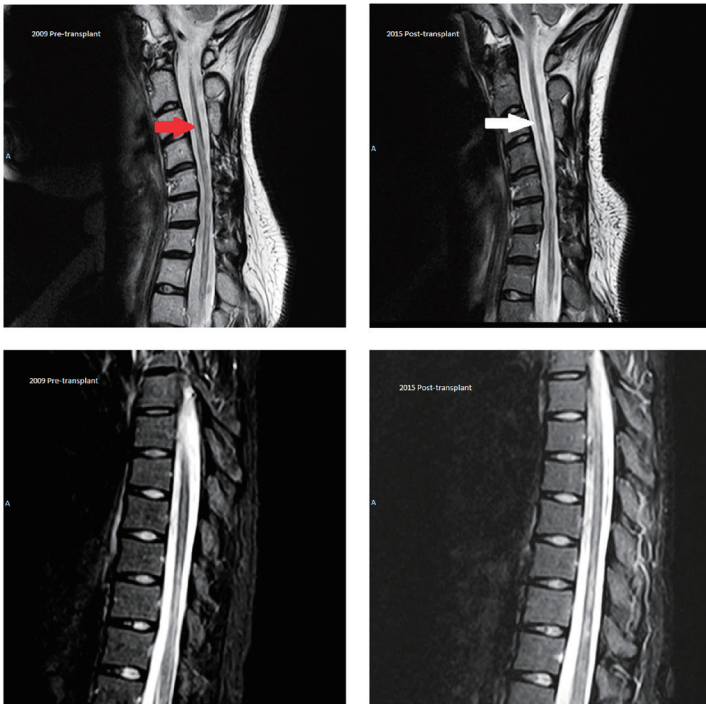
(MRI cervical spine pre- and post-transplant showed stable T2 hyperintensities extending from C2 to T4.
